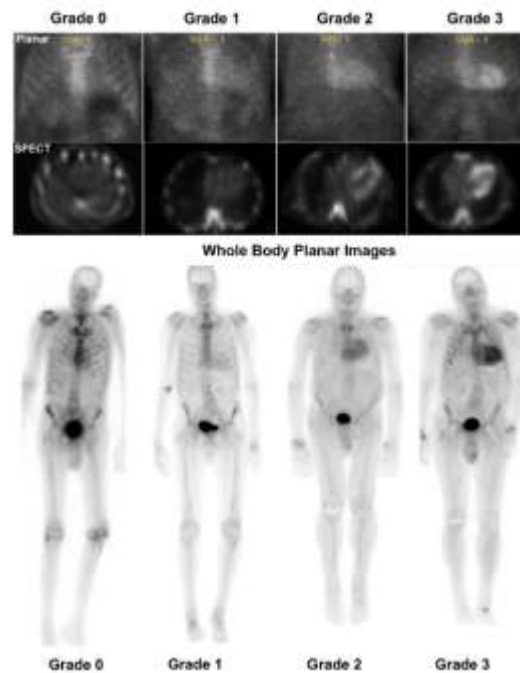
^{99m}Tc-PYP capture on planar and SPECT imaging.^{9,20}
